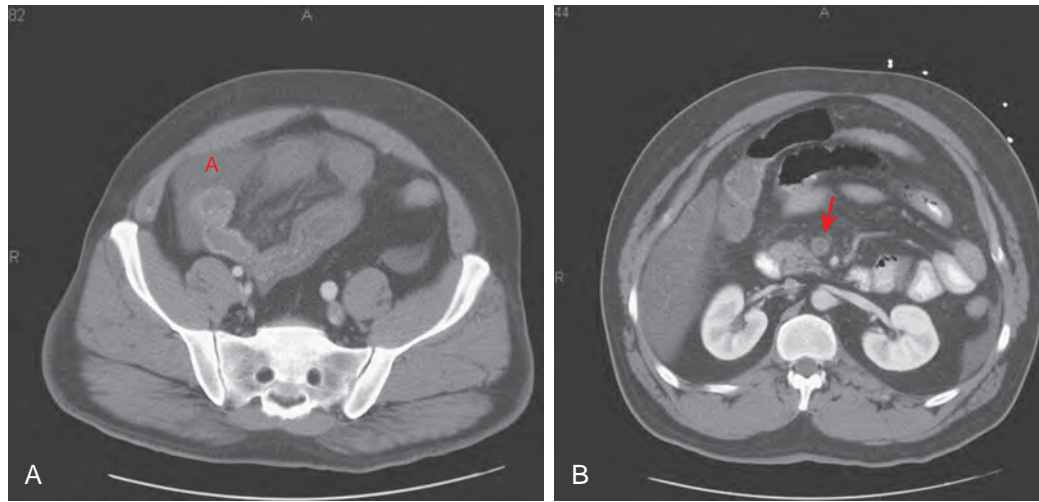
Small bowel ischemia due to thrombosis of the superior mesenteric vein. A. This enhanced CT scan shows circumferential thickening of ileal small bowel loops within the pelvis. Pelvic ascites (A) is also present. B. There is absent enhancement of the superior mesenteric vein (arrow) caused by intraluminal thrombus.
